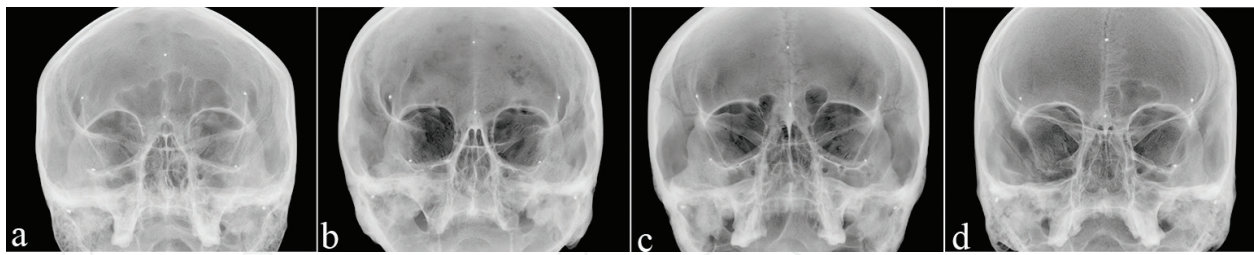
Industrial digital radiographs of dry adult male skulls oriented in Caldwell's view: (a) frontal sinus of normal size; (b) bilateral aplasia of the frontal sinus; (c) underdeveloped frontal sinus of the orbital type in a metopic skull; and (d) right-sided frontal sinus aplasia in a metopic skull.
